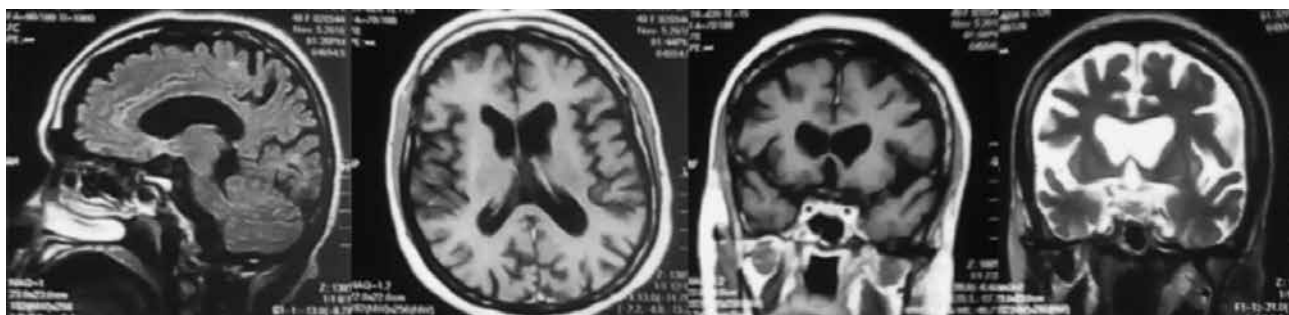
cMRI of the patient in which multiple lesions were evidenced compromising the peritrigonal white matter of both hemispheres, being hyperintense in FSE T2 and in FLAIR, signs of cortical atrophy, atrophy of caudate nucleus. The cMRI study was performed with a Toshiba Flexart 0.5T device using FSE T2 and FLAIR sequences in axial and coronal planes. Intravenous contrast material (Gadolinium) was injected*
